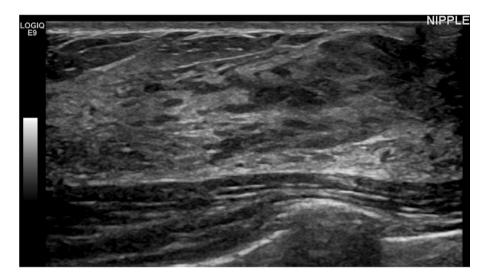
Left breast ultrasound at subareolar area of reported pain: normal fibroglandular tissue throughout central and superior L breast, no masses or suspicious findings.
